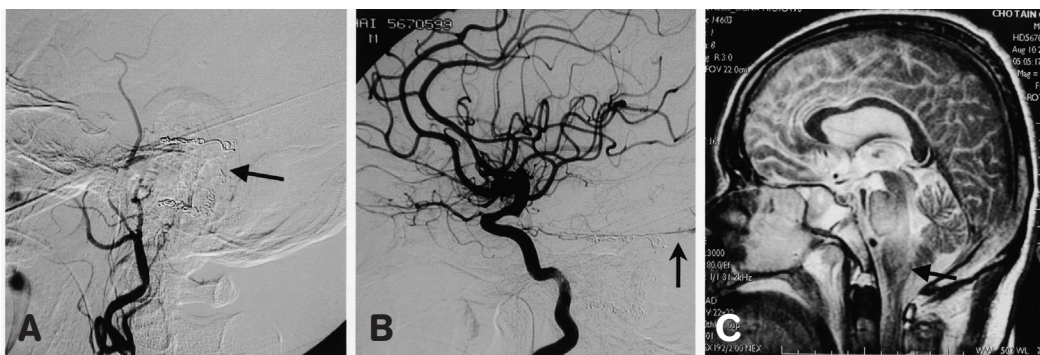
(A) Left ECA angiography (lateral view) showed successful transvenous embolisation of the left superior petrosal sinus and sigmoid sinus (arrow) with obliteration of dural AV fistula. (B) Left ICA angiography (AP view) showed obliteration of the dural AV fistula between left ICA siphon dural branch (arrow) and superior petrosal sinus. (C) Sagittal T2-weighted (4500/120 [TR/TE]) MR image showed reduction of edematous changes in the medulla oblongata (arrow).
